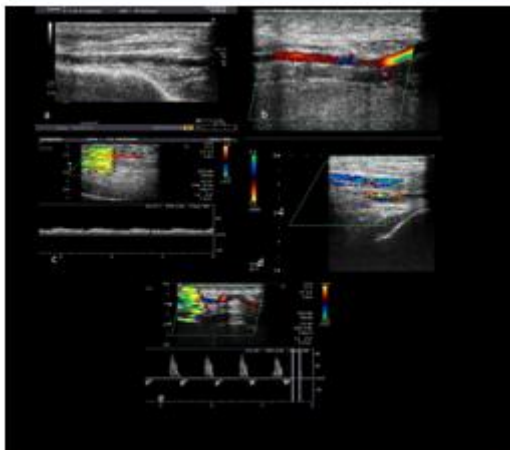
Buerger's disease. A 38 year male with h/o smoking for 50 years, presented with complaints of leg pain , swelling, claudication. a & b) B mode longitudinal image of PTA showing vessel wall thickening & irregular lumen, c) colour flow image of ATX, d) Spectral doppler image showing low velocity monophasic flow, e) colour flow image showing collateral vessels, f) Spectral colour doppler image of distal PTA, showing raised peak systolic velocity.
